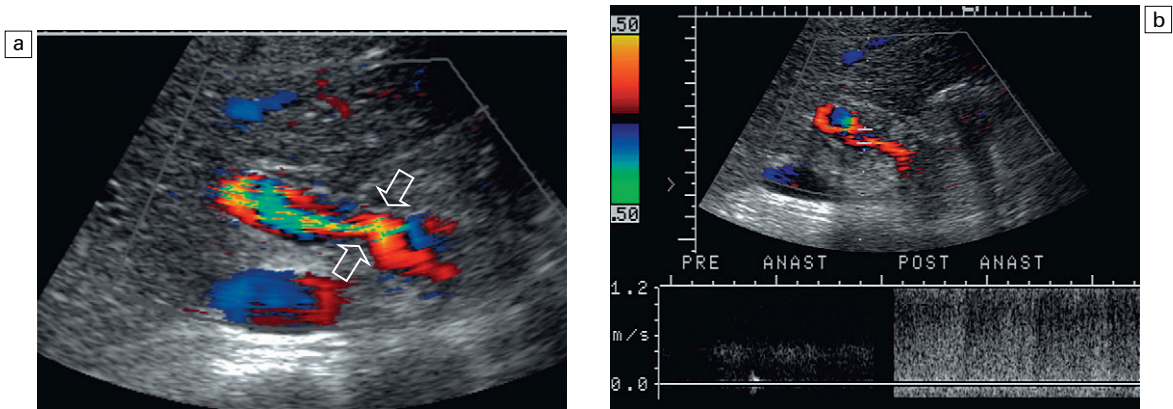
(a) Colour Doppler image of the portal vein in the region of the anastomosis. Note the area of relative narrowing at the point of anastomosis (arrows). A high velocity jet with aliasing is seen shooting into the donor portal vein. Spectral Doppler tracing on either side of this anastomosis (b) had to be set low to project the relatively slow preanastomotic portal vein flow. As a result, the postanastomotic (poststenotic) tracing shows a high degree of aliasing. This comparative velocity measurement on one tracing can be achieved by moving the sample volume across the anastomosis and allows an accurate comparison of pre- and postanastomotic velocities. Velocity gradients of less than fourfold are not likely to be clinically significant.
